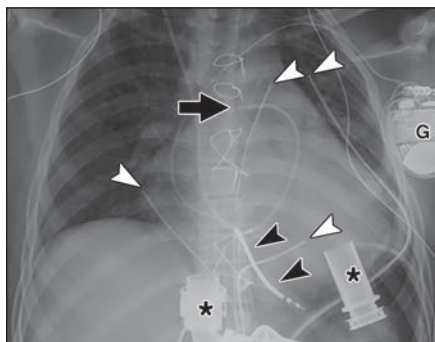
17-year-old boy with cardiomyopathy who has undergone left ventricular assist device (LVAD) placement and has appropriately positioned lines and tubes. Frontal chest radiograph shows cardiomegaly, median sternotomy wires, pulmonary artery catheter (arrow) with tip in main pulmonary artery, automated implantable cardioverter defibrillator with generator (G) and single lead with radiopaque shock coil (black arrowheads) in right ventricle, LVAD (asterisks), and four chest tubes (white arrowheads).
